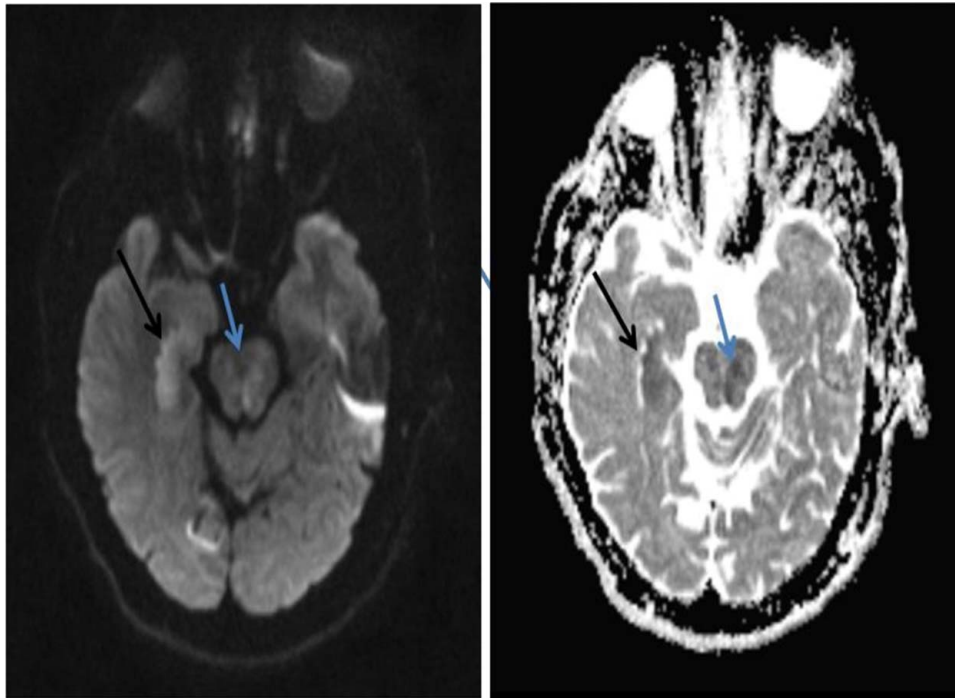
DWI (left) and ADC (right) sequences of brain MRI show small areas of restriction diffusion. ADC, apparent diffusion coefficient; DWI, Diffusion-weighted imaging.
